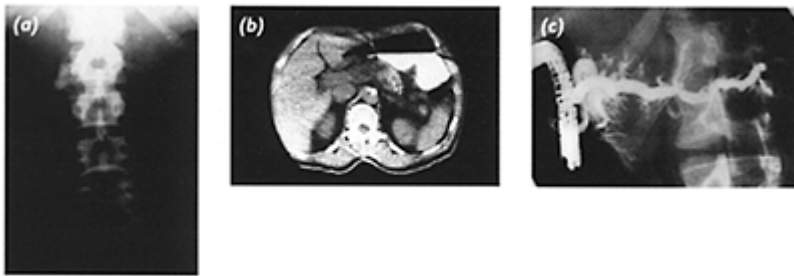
Establishing the diagnosis in chronic pancreatitis. (a) Plain X-ray. Calcification is identifiable in the pancreas. (b) CT scan. The pancreas is atrophic. (c) ERCP. The pancreatic duct is irregular with dilated side branches.*
